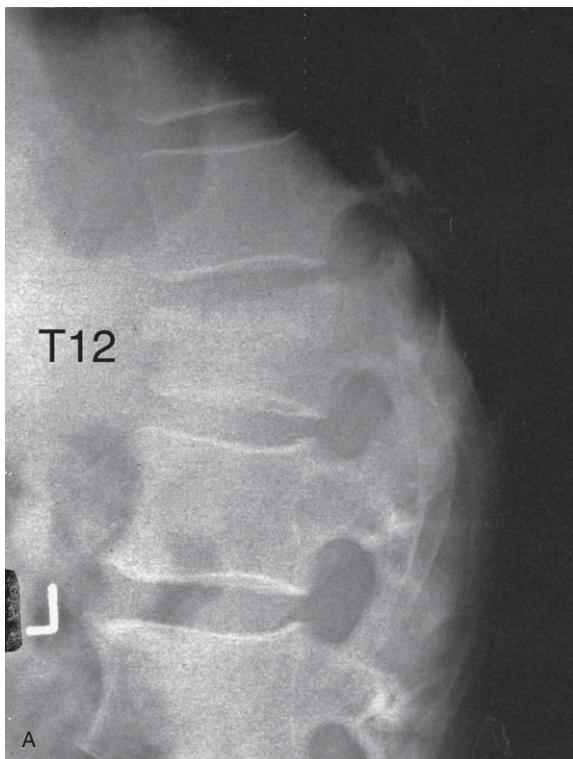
(A) Thoracic spine lateral plain X-ray image showing the compression fracture of the T12 vertebral body with anterior wedging and disruption of George's line. (B) Thoracic spine CT axial image through the T12 vertebral body that shows the burst fracture of the body of the T12 vertebra, with considerable retropulsion of a posterior bony fragment into the spinal canal causing a reduction of cross-sectional area of approximately 35%. Small arrows show part of the fracture line. The retropulsed posterior fragment in the spinal canal lies posterior to the semicircular black line that represents the approximate area at which the anterior part of the spinal canal would normally be seen. A = anterior; C = spinal cord; P = posterior; R = right side of patient. The insert shows the level of the axial scan slice.
